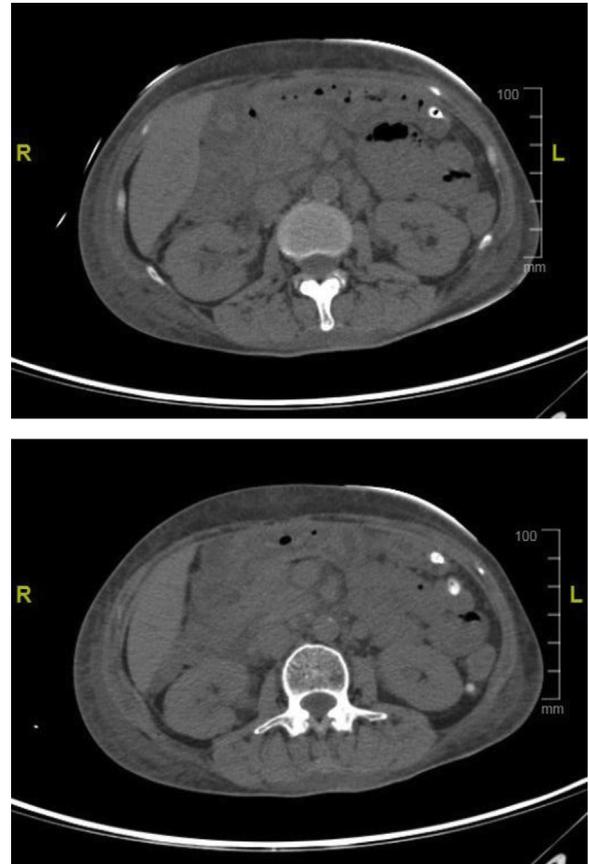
CT of abdomen and pelvis without contrast demonstrating bowel edema.
